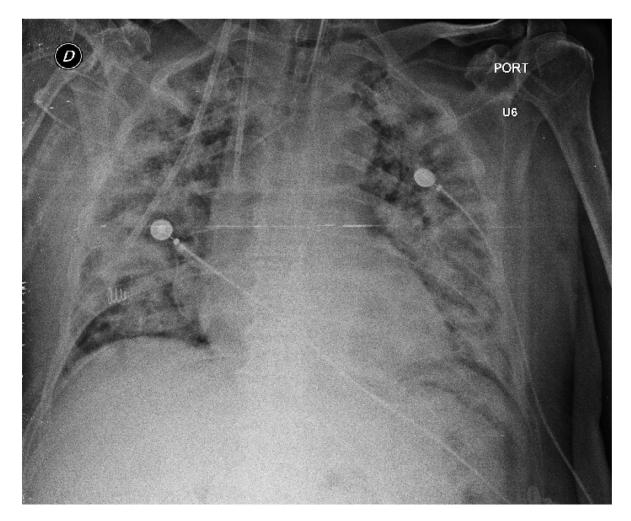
Portable chest X-Ray (AP projection): Multilobar consolidations. Also note enteral probe and endotracheal tube.
